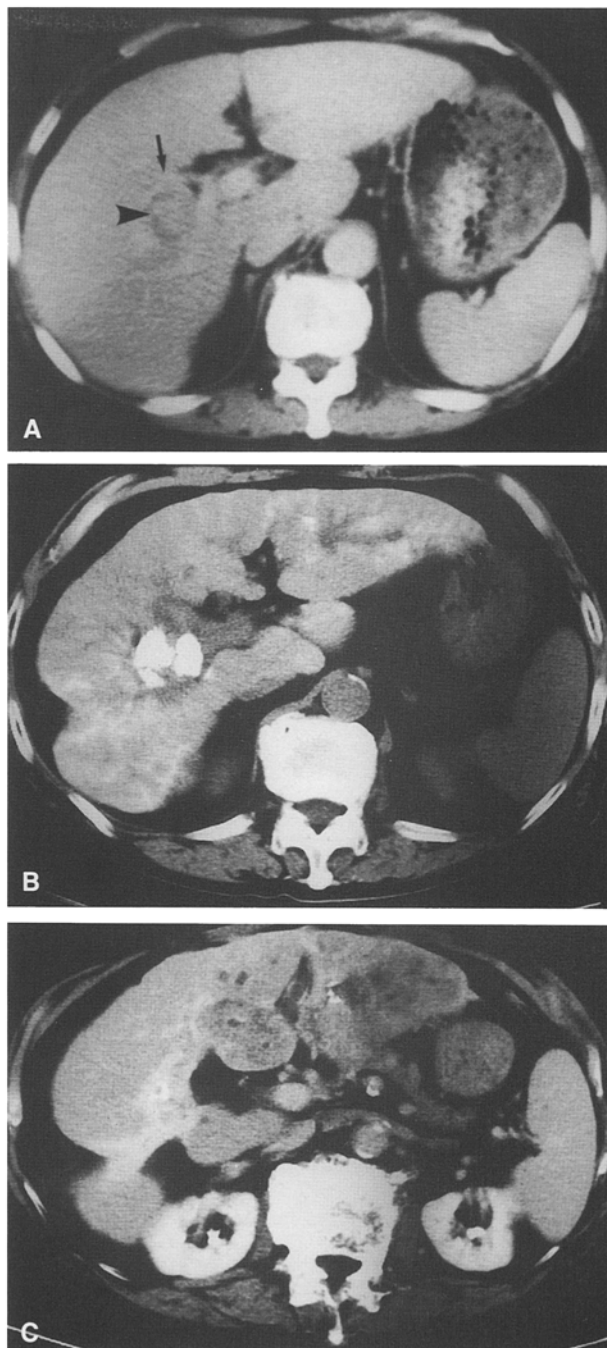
A 61-year-old man with nodular hepatoma treated by iodized oil/cisplatin with Gelfoam particles. A Contrast-enhanced CT shows a nodular mass in the right hilum (arrowhead). The anterior branch of the portal vein was occluded (arrow). The right hepatic artery was embolized using iodized oil/cisplatin with Gelfoam particles. A small amount of iodized oil was given in the left hepatic artery for detection of small metastatic tumors. B Precontrast CT obtained 1 month after TAE shows atrophy in the anterior segment of the right lobe. A small amount of iodized oil is seen in the left lobe as well as the right lobe. The patient received TAE twice after this CT. C Contrast-enhanced CT obtained 26 months after initial TAE shows marked atrophy in the anterior segment of the right lobe. The posterior segment is also atrophic. A new lesion is seen in the left lobe.
